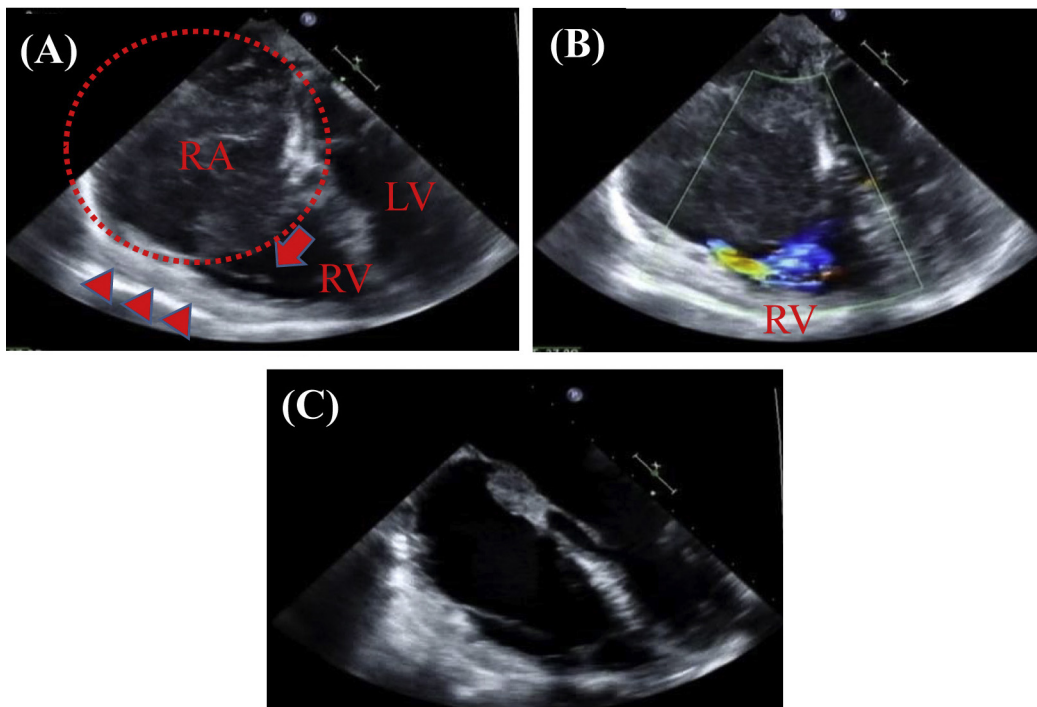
Intraoperative transesophageal echocardiograms. (A) Preoperatively, the tumor occupied the right atrium (RA; circle) and the displaced tricuspid valve (arrow). The right ventricle (RV) wall was thick (arrow head). (B) Marked tricuspid stenosis was noted. (C) Postoperatively, tricuspid valve function was restored but with thickened RV wall. LV, left ventricle.
